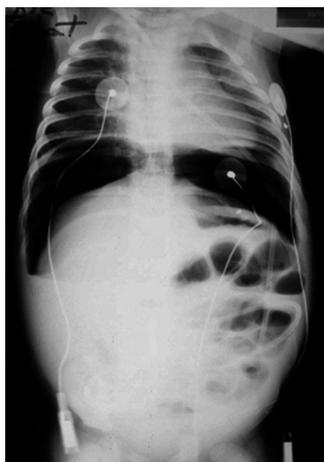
Patient 6. Three-month-old male with history of operated hypertrophic pyloric stenosis, shunted for subdural collection. In addition, patient had enteritis at the time of operation. Five days after surgery, he presented with acute abdomen and high-grade fever. Plain abdomen radiographs showed obvious pneumoperitoneum. The child underwent removal of shunt and emergency laparotomy with suture of bowel perforation. A new subduroperitoneal shunt was inserted 3 weeks later without complication.
